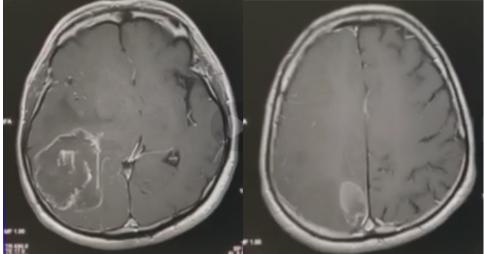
Cranial MRI with contrast on Post-gad contrast showed a hyperintense signal surrounding the fairly defined nodule on both right high parietal lobe and right parieto-temporo-occipital lobe.
